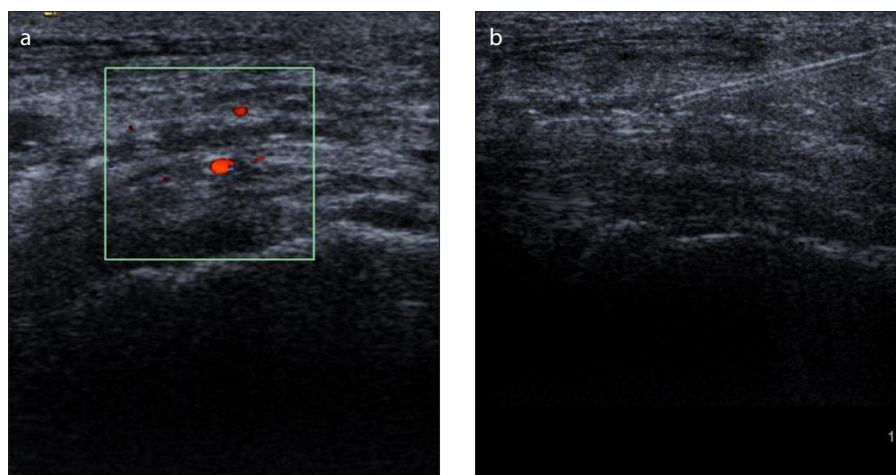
a, b. Totally occluded artery in color Doppler examination (a), percutaneous puncture with needle into a totally occluded artery (b).
